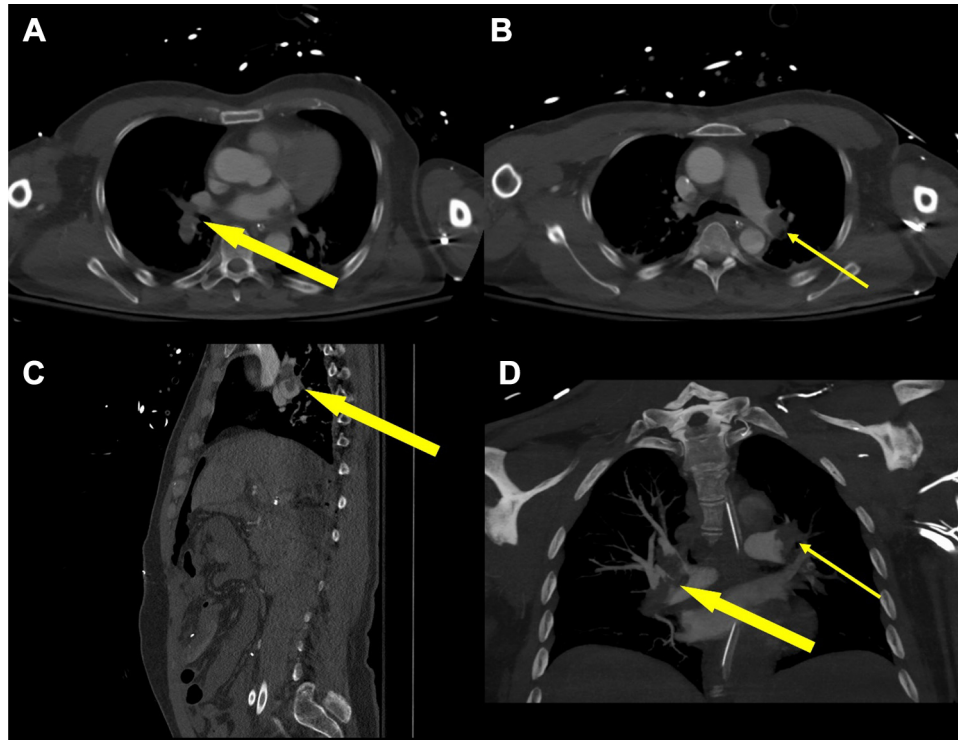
Computed tomography angiography (CTA) demonstrating the extent of the tumor embolus to the right (*large arrows*) and left (*narrow arrows*) pulmonary arterial circulation, resulting in a massive pulmonary embolus. A and B, Representative axial images. C and D, Sagittal and coronal images, respectively.
